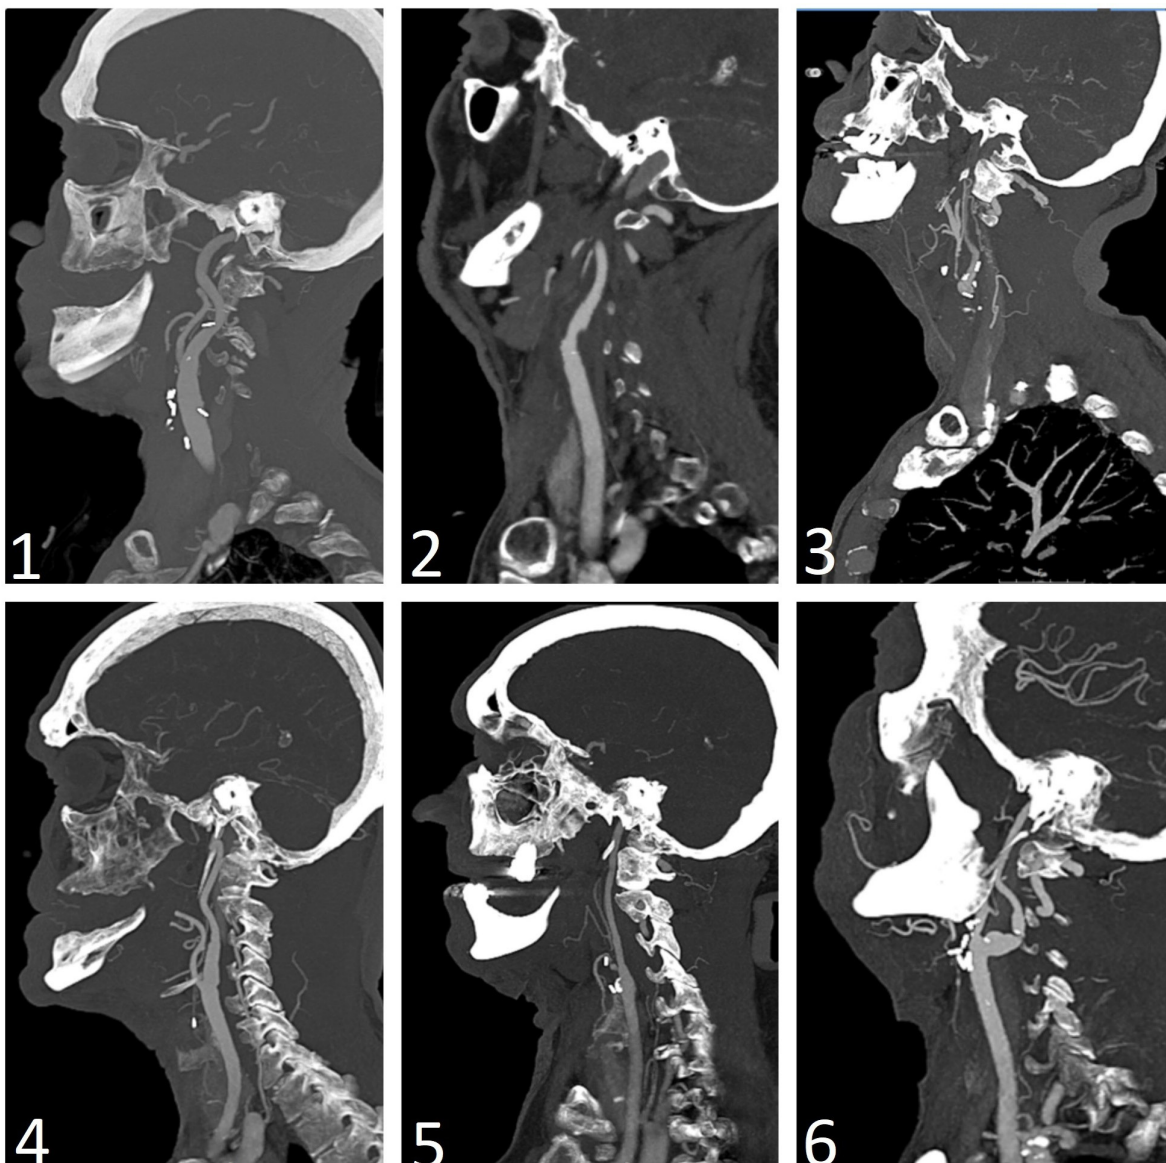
CTA images (sagittal section) of postoperative residual lesions (Cases 1-6 in sequence)
